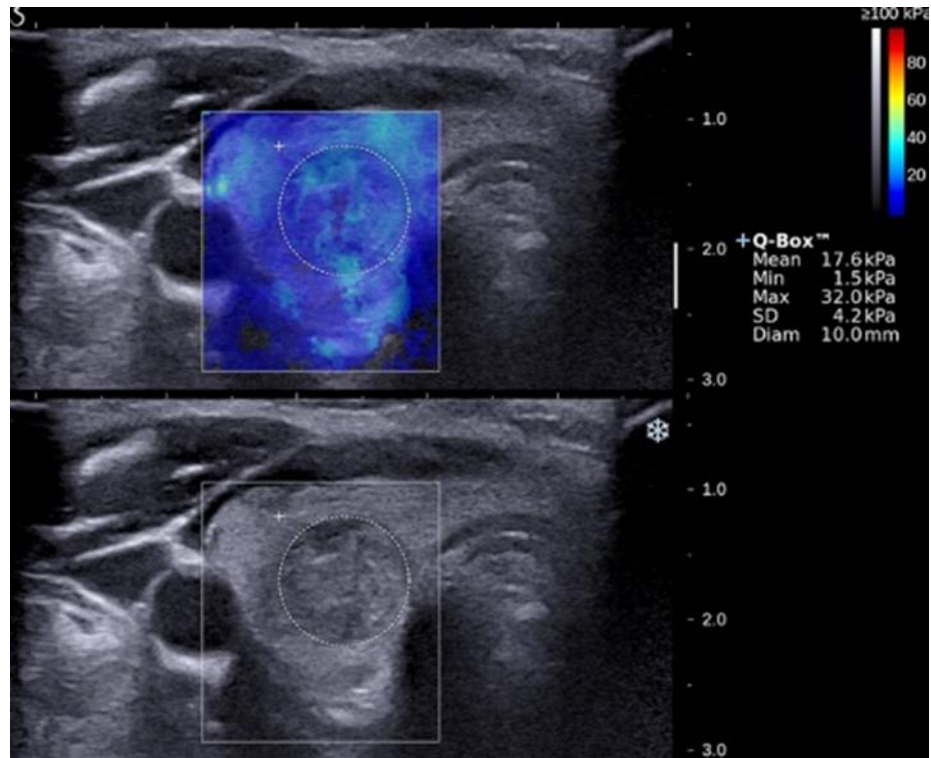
Transverse elastogram (upper) and grey-scale sonogram (lower) of a benign nodule in the right thyroid lobe of a 37-year-old patient. The value of elasticity indices ( $E_{\text{maximum}} = 32 \text{ kPa}$  and  $E_{\text{mean}} = 17.6 \text{ kPa}$ ) were lower than the respective cut-off values reported in the present study.
